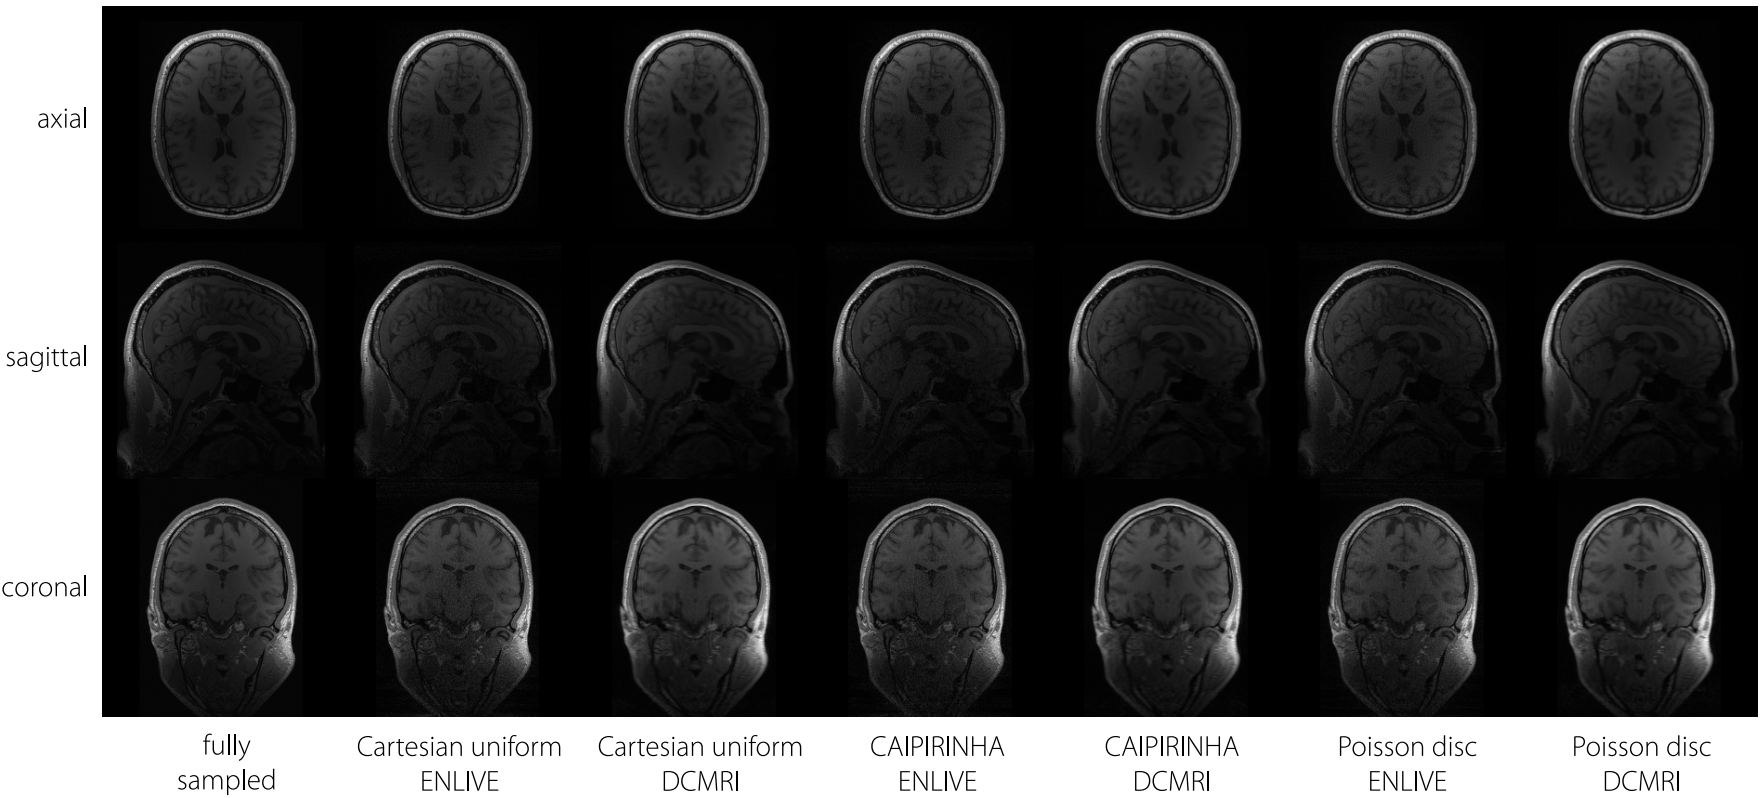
T1-weighted images of a single volunteer retrospectively undersampled with 9x acceleration using different k-space undersampling schemes and reconstructed using ENLIVE and DCMRI. Undersampling with 3x3 patterns (Cartesian and CAIPIRINHA) or 9x undersampled Poisson disc, each with fully sampled auto-calibration region in k-space center spanning 6.5% of the sampling matrix. ENLIVE tended to shift the average image intensity for slices with little overall signal (inferior and superior) leading to stripe like effects in affected regions of the coronal and sagittal views.
